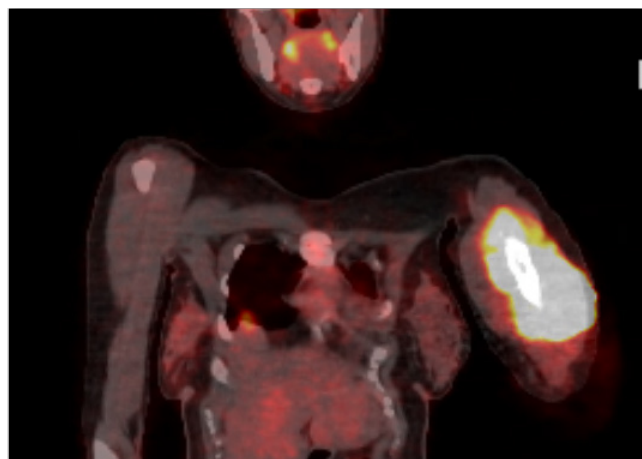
Postpartum fluorodeoxyglucose (FDG) PET-CT imaging
